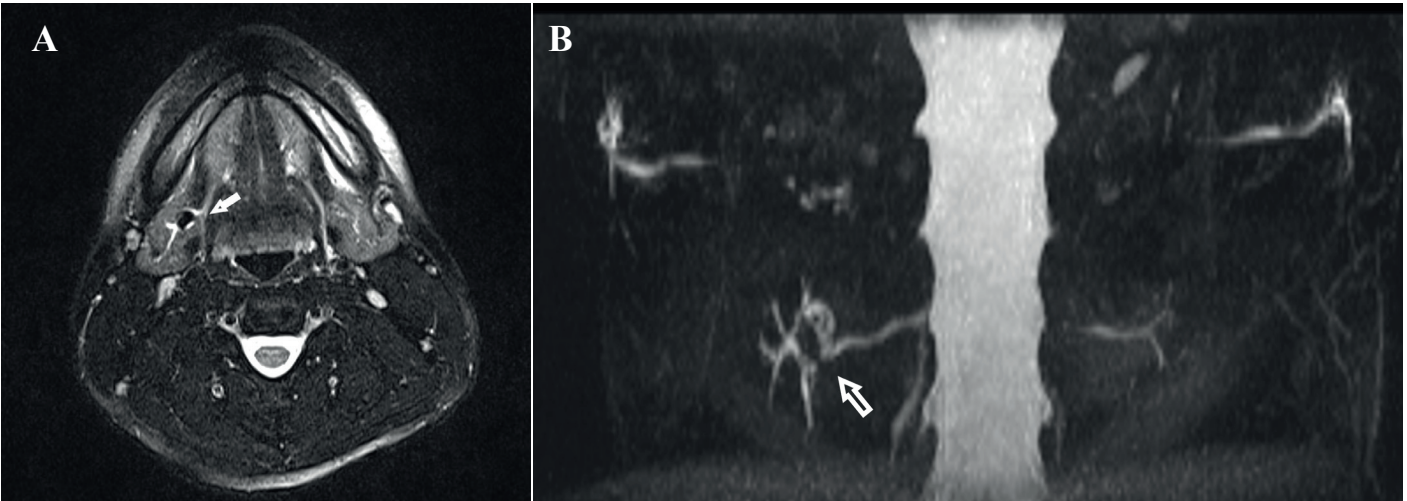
A. T2 fatsat axial image showing a stone in the hilum of the right submandibular gland; B. 3D MRI sialography showing a stone in the hilum of the right submandibular gland and moderate intraparenchymal ductal dilatation
